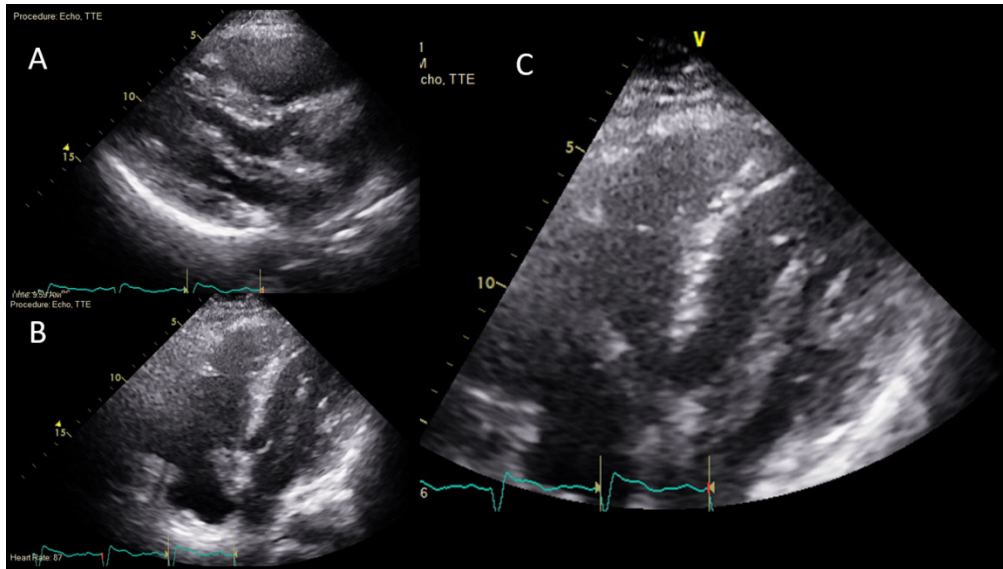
TTE in (A) parasternal long axis and (B, C) apical 4 chamber views showing a continuous elongated mass traversing both the inter-atrial septum and mitral valve.
